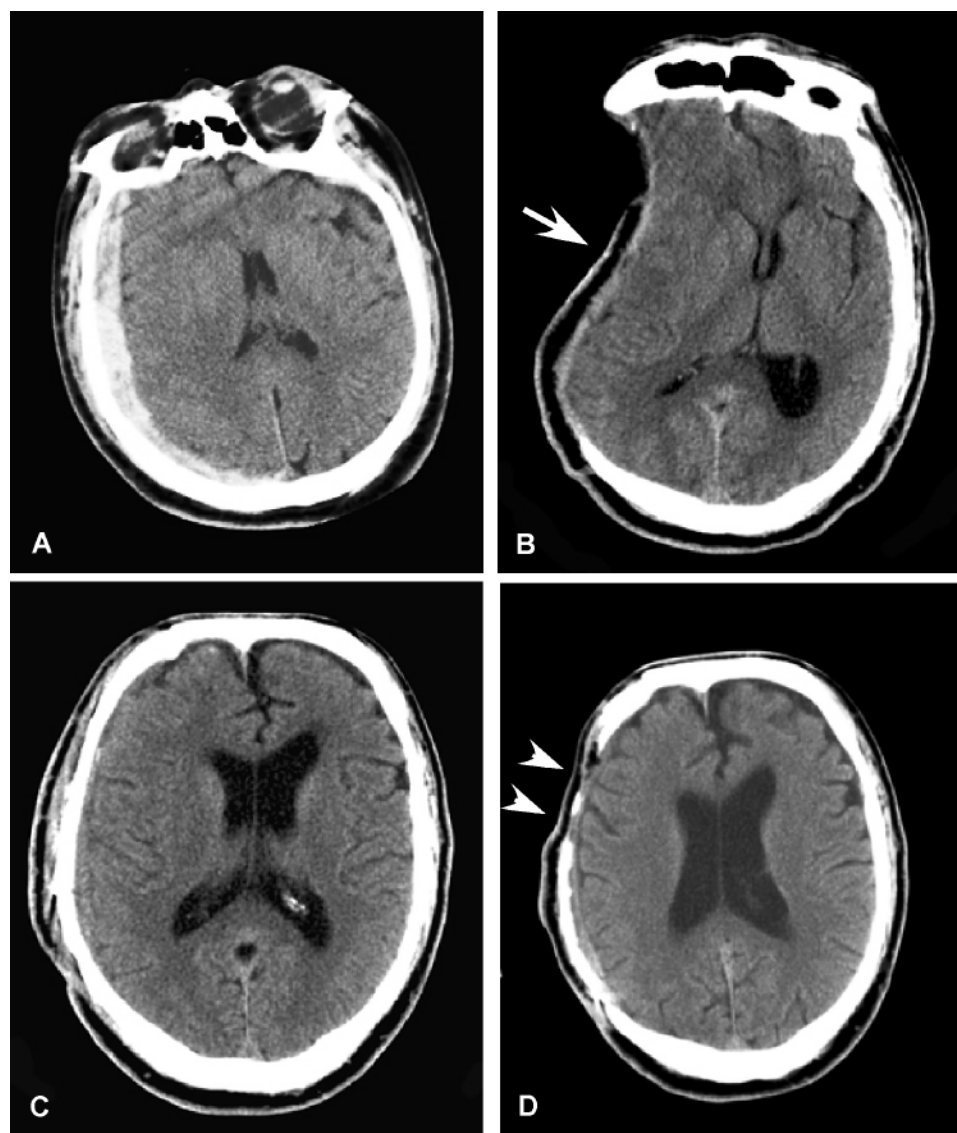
Sinking scalp flap. A: Preoperative noncontrast CT scan demonstrating a right acute SDH, which was evacuated and the bone left off as a prophylactic measure against subsequent intracranial hypertension. B: A CT scan without contrast obtained several months later demonstrates a sunken parenchymal contour (*arrow*) with ~ 1.5 cm of midline shift. C: After autologous cranioplasty repair of the skull defect, a CT scan showed restoration of both the sunken brain contour and the midline shift. D: Within 2 months following cranioplasty, noncontrast CT imaging began to show signs of partial resorption (*arrowheads*) of the replaced bone flap.
